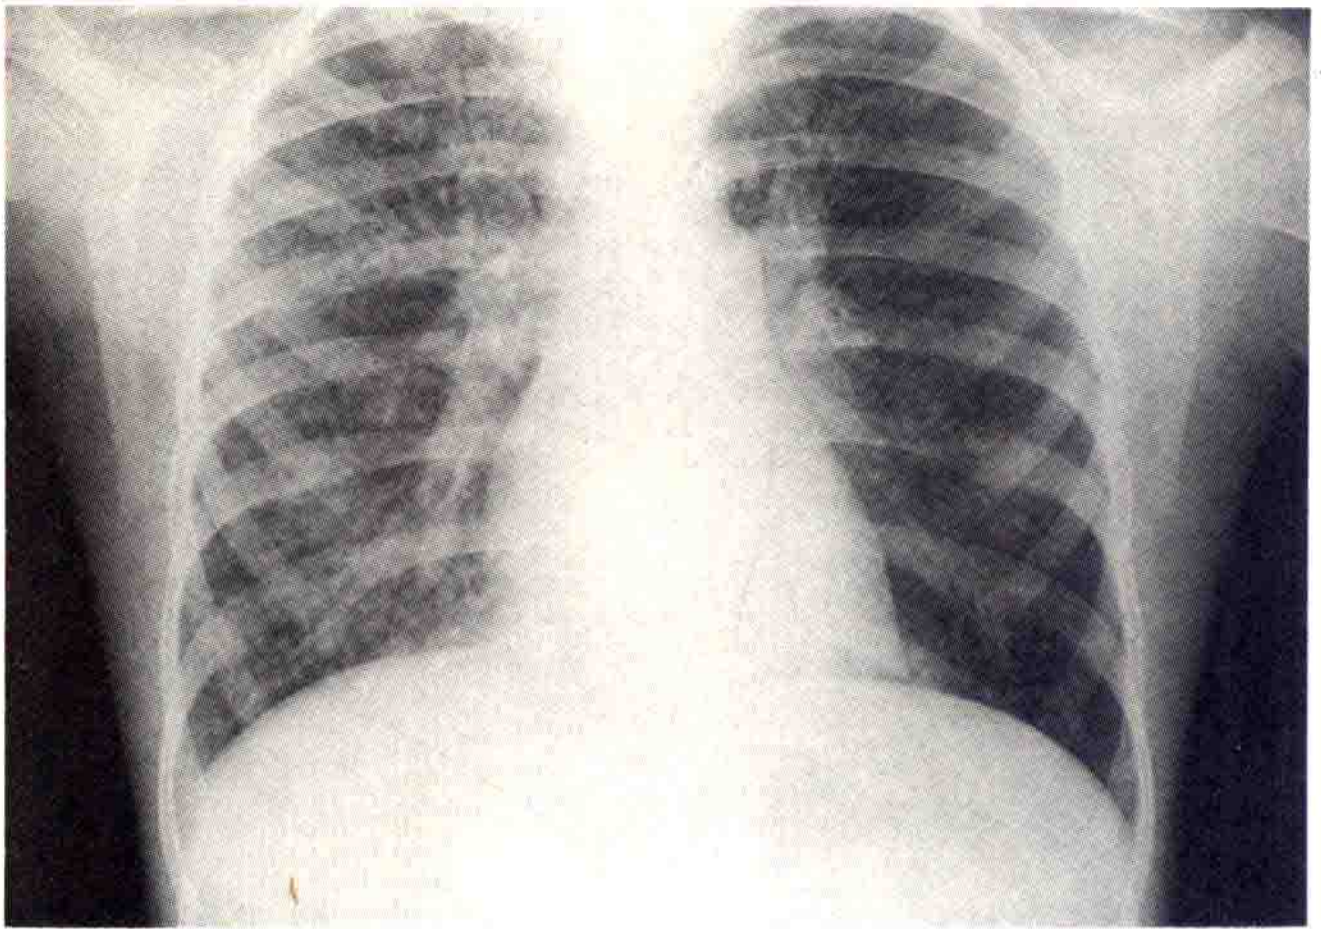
Viral pneumonia. Some viruses, such as influenza, can cause pneumonia in the normal host while others, such as cytomegalovirus cause lung disease mainly in the immunosuppressed. The radiograph, as here, usually shows diffuse bilateral abnormalities and this appearance could be caused by a number of different viral and other pathogens.
